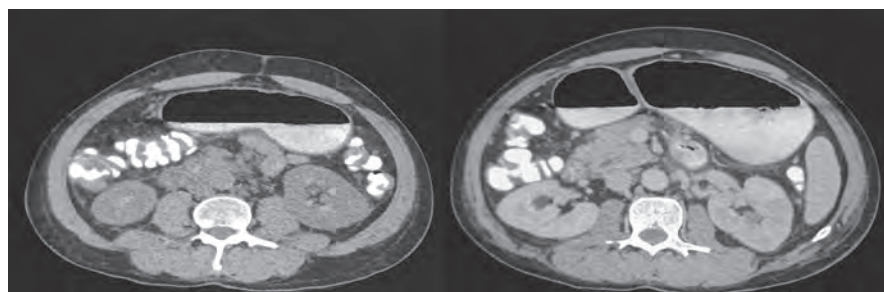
Computed tomography (CT) of the abdomen
